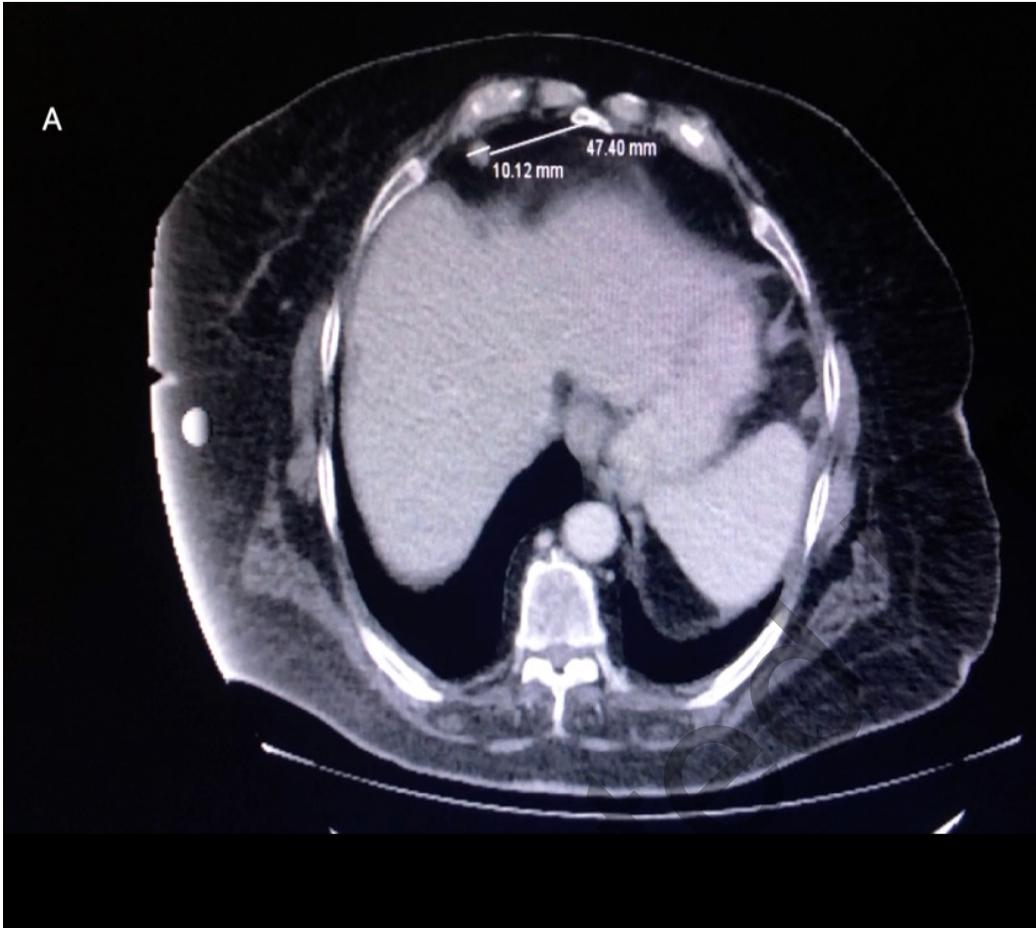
Enlarged right costophrenic lymph node approximately 5 cm from the xiphoid and sternum on computed tomography
